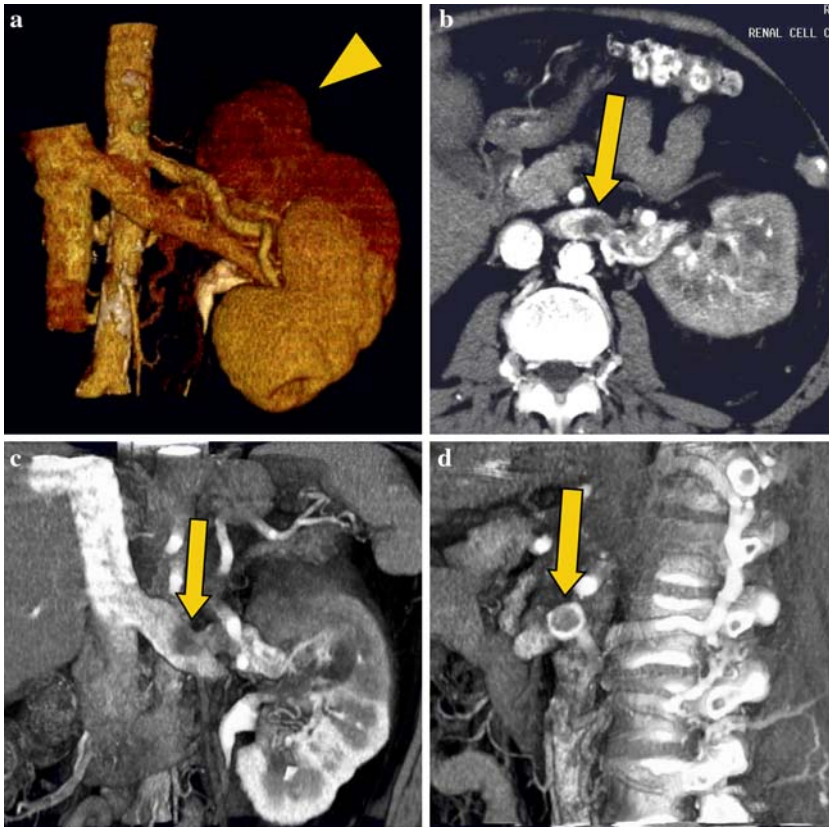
Renal cell carcinoma with renal vein thrombus. CTA of the abdominal aorta and left kidney. Volume rendered CTA (A) demonstrates a hypervascular mass in the upper pole of the solitary left kidney. Axial (B), coronal (C), and sagittal (D) CT images of the left renal vein demonstrate the extent of nonocclusive venous thrombus.
